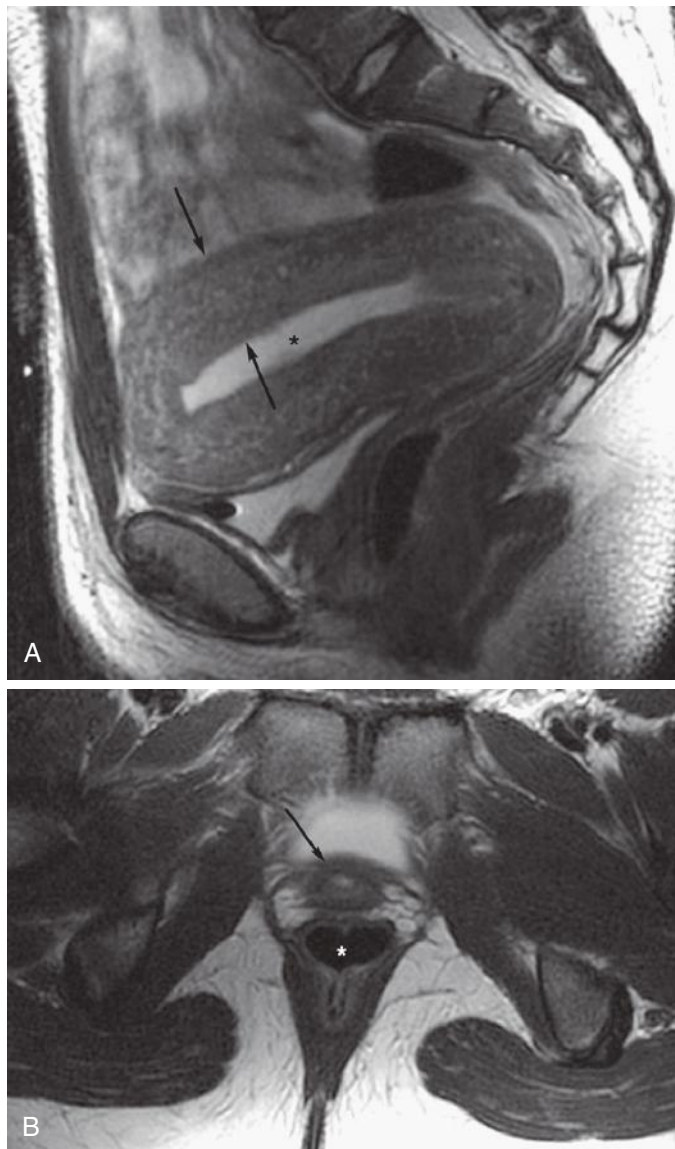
Vaginal agenesis. Sagittal T2-weighted (A) and axial T2-weighted (B) images demonstrate mild distention of the uterine cavity (asterisk on A) and thickening of the myometrium (arrows on A) as well as absence of the vagina between the normal urethra (arrow on B) and rectum (asterisk on B).
